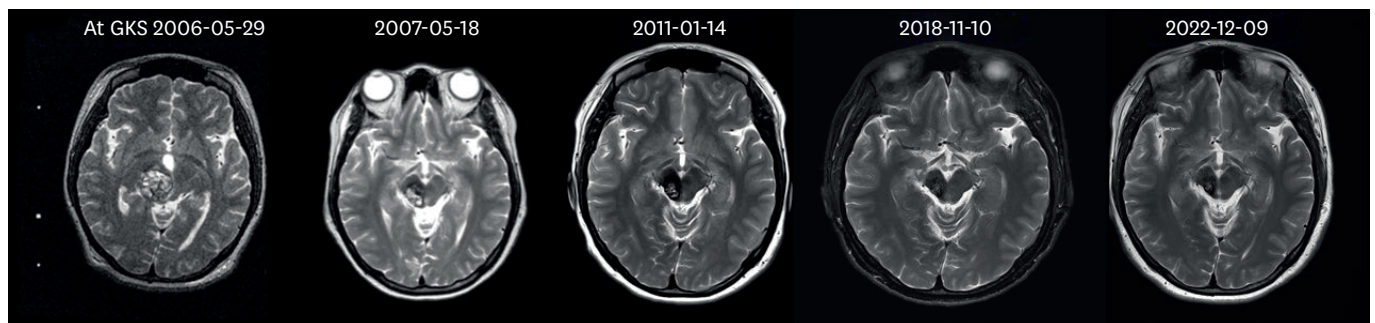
Volume reduction and stabilization of cerebral cavernous malformation after GKS. A 6.4 cm³ cavernous malformation in the right midbrain was detected in a patient presented with left hemiparesis. GKS was performed with a marginal dose of 13 Gy to the 50% isodose line. Serial T2-weighted magnetic resonance imaging shows progressive volume reduction and obliteration of the core portion.
